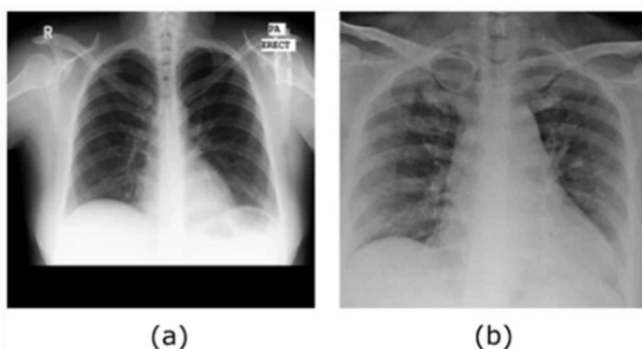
a) COVID-19 Negative X-ray image, b) COVID-19 Positive X-ray image
